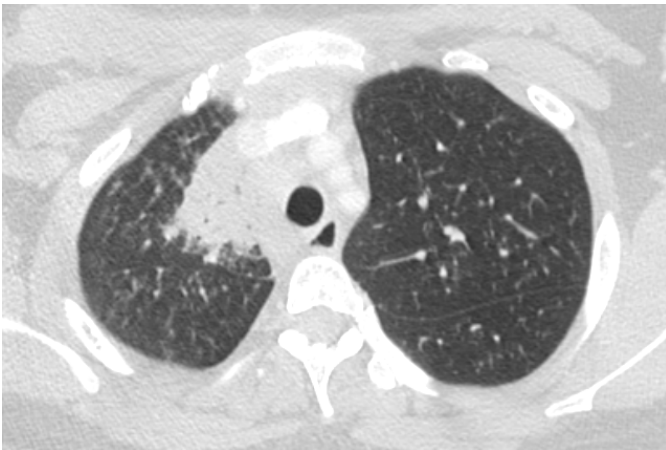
Chest CT scan without contrast.
